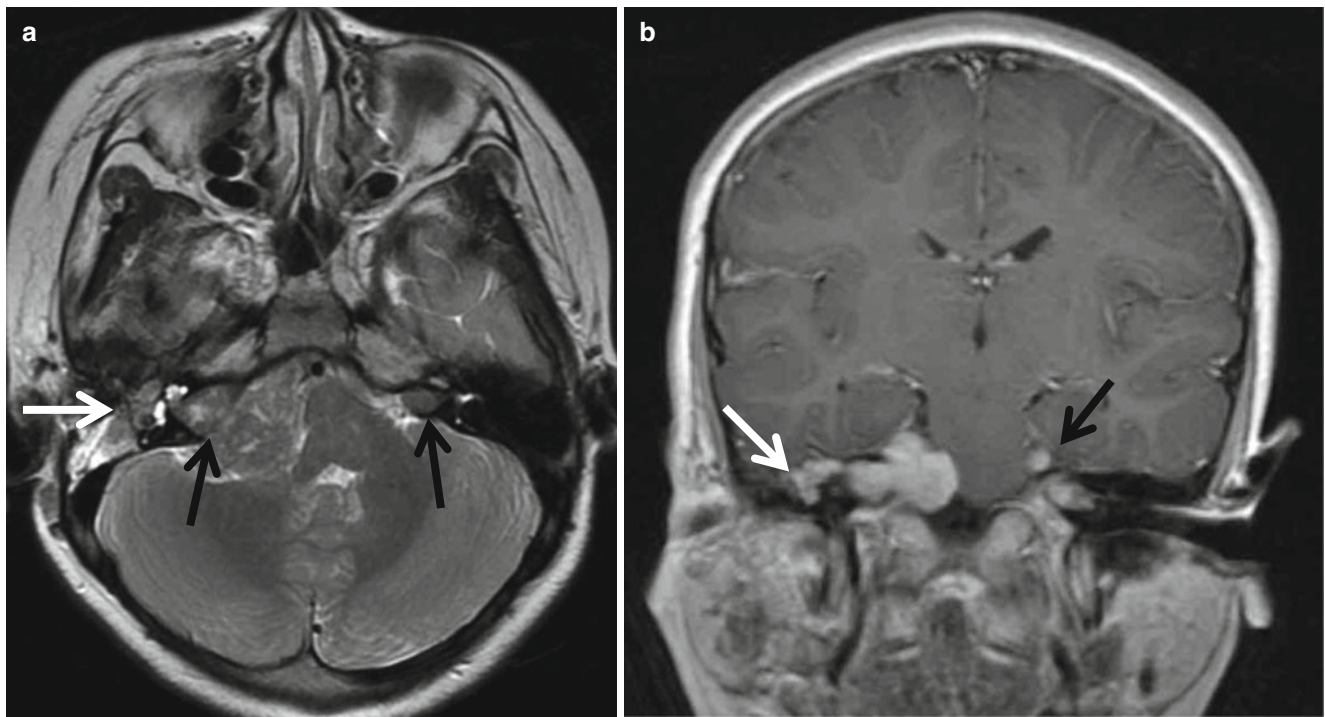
Multiple cranial nerve tumors in patient with type 2 neurofibromatosis. (a) T2-weighted coronal image shows bilateral internal auditory canal masses (*black arrows*) of isointensity compared to the brain. The right one is extending to the CPA area compressing
